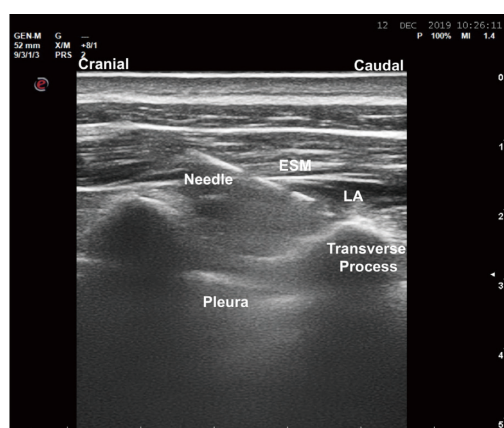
Ultrasound image of ESPB. ESM, erector spinae muscle; LA, local anesthetic; ESPB, erector spinae plane block.
